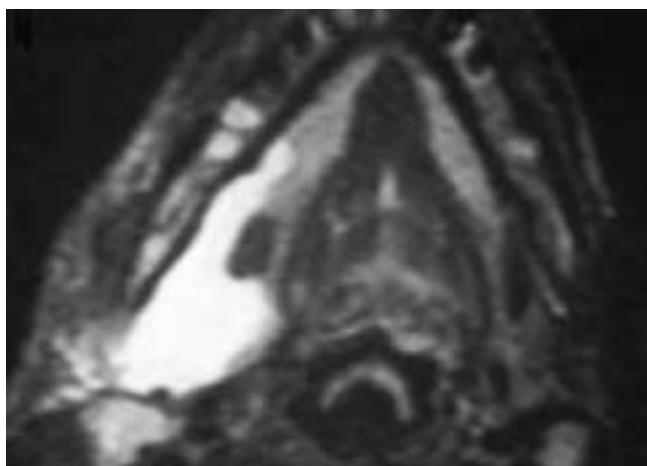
Axial T2-weighted MR image shows a high signal intensity mass in the right lateral floor of the mouth. The mass extends dorsal to the mylohyoid muscle and projects into the submandibular triangle. This patient had a ranula.
